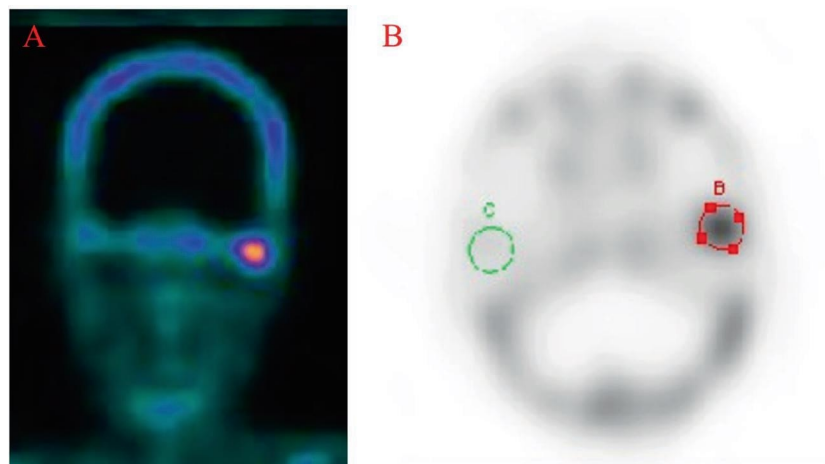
Bone scintigraphy image (^{99m}Tc): (A) Bone scintigraphy shows an increase in uptake of radioactive isotope in the left TMJ region. (B) Axial image: Radioactive uptake in the condyle on the affected side is found to be 3.69 times greater than on the unaffected side.
